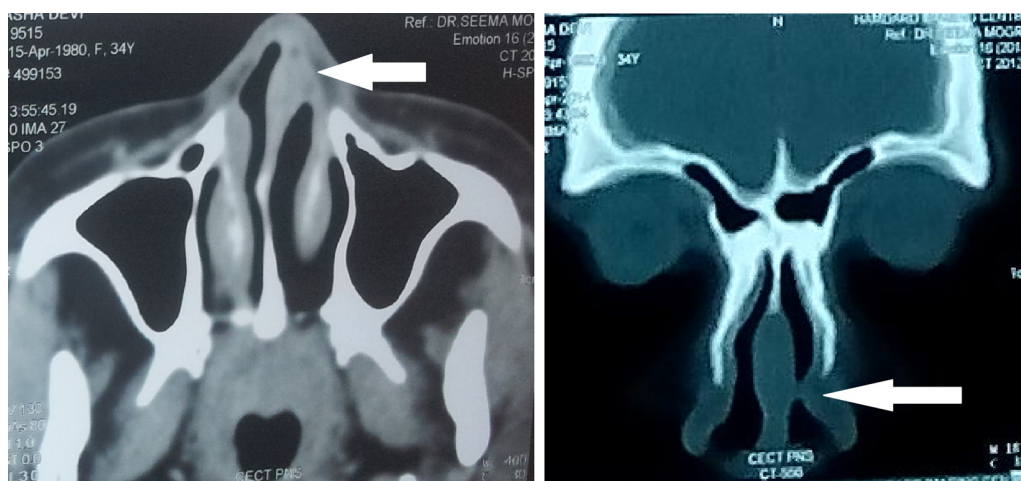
CT sections showing the site of lesion with normal sinuses.
